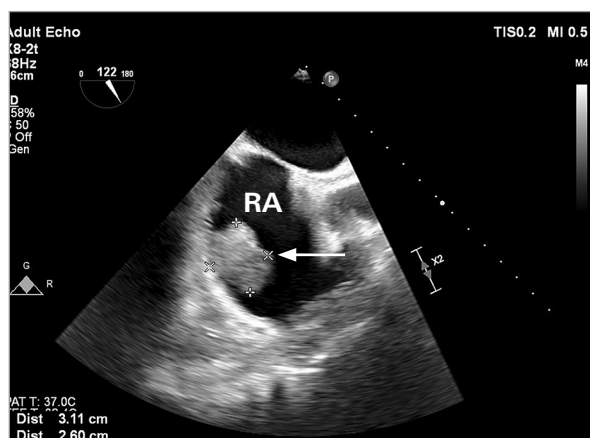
Transesophageal echocardiography after 4 months of anticoagulation shows the RA mass (arrow) with minimal change in size.
